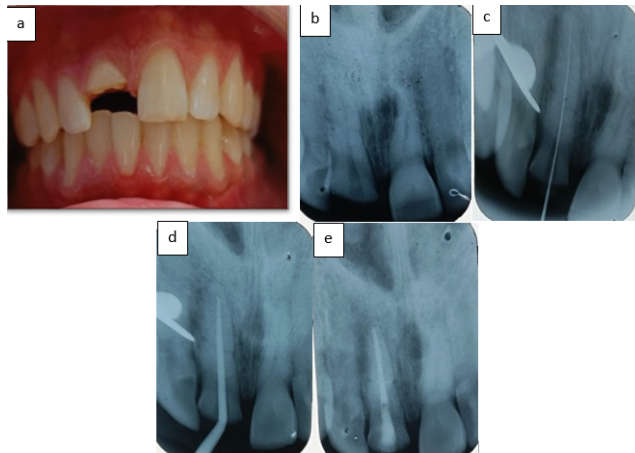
a: preoperative photograph; b: Preoperative radiograph showing horizontal root fracture at the middle region 11; c: Canal negotiated through fracture fragment with 15k; d: Master cone 50 / .02; e: Obturation with bioceramic sealer.
